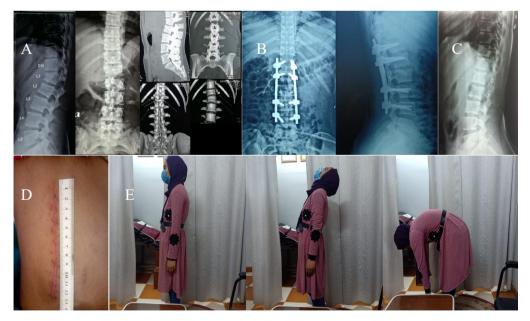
Female patient, 16 years old with fracture of L1 AO type B1. She was neurologically intact and treated by long segment fixation from D11 to L3 with satisfactory clinical outcome. (A) Preoperative X-ray and CT scan. (B) Postoperative plain X-rays. (C) Plain X-ray after metal removal. (D) Length of surgical wound. (E) Spinal motion after metal removal
